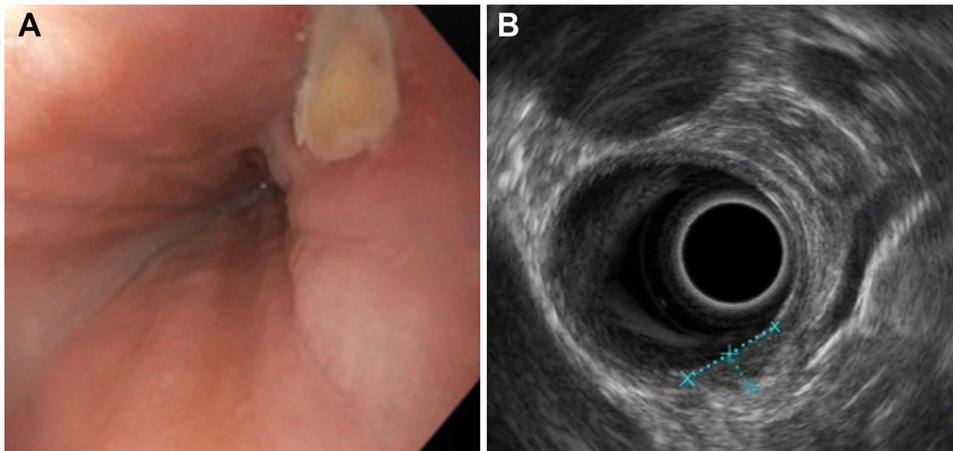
Day 3 following pulmonary vein isolation. Thermally induced esophageal ulcer (A), associated with edema (10 × 4 mm, blue-dotted lines) of the esophageal wall (B), visualized in endoscopic ultrasound.
